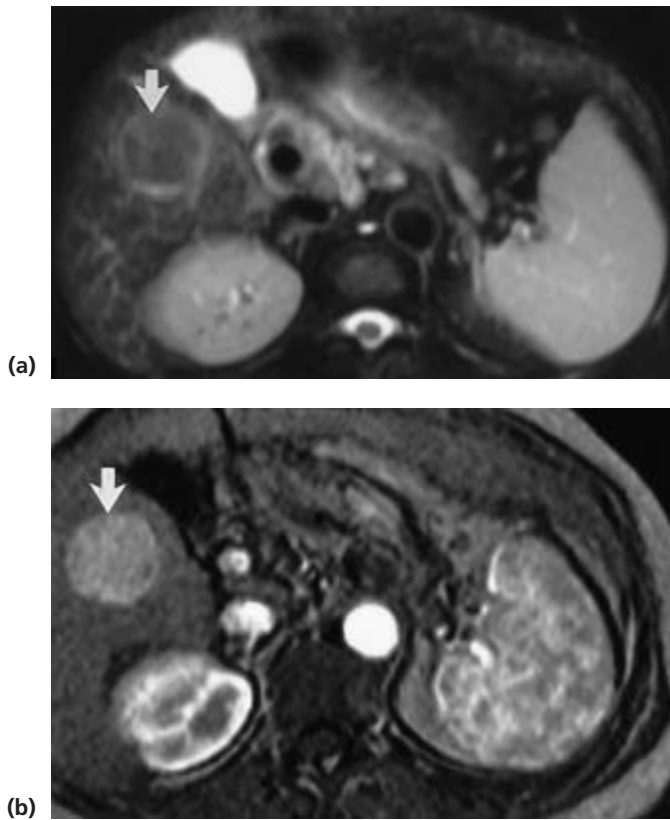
MRI of small hepatocellular carcinoma in segment 4 (arrows). (a) T₁W pre-contrast. (b) Gadolinium contrast enhanced – arterial phase.
